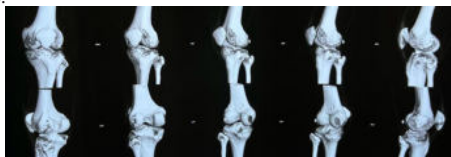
3D reconstruction of CT left knee shows tibial
